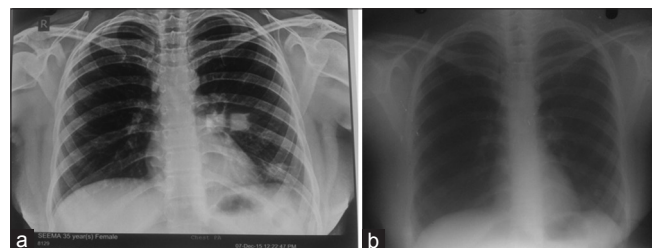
(a) Perioperative chest X-ray showing: a small patch of infiltration is seen in the left lower zone. Right lung field is clear. (b) Postoperative chest X-ray after 13 months
